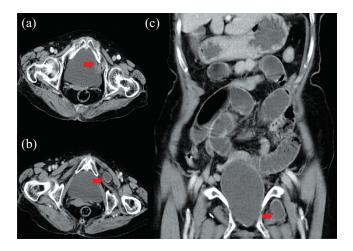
The axial CT scan of abdomen showing incarcerated bowel loop protruding into the left obturator foramen (a, b, red block arrow). The longitudinal CT image of abdomen demonstrated a small bowel loop between the left obturator externus and pectineus muscles and diffused dilatation of small bowel loops (c, red block arrow).
